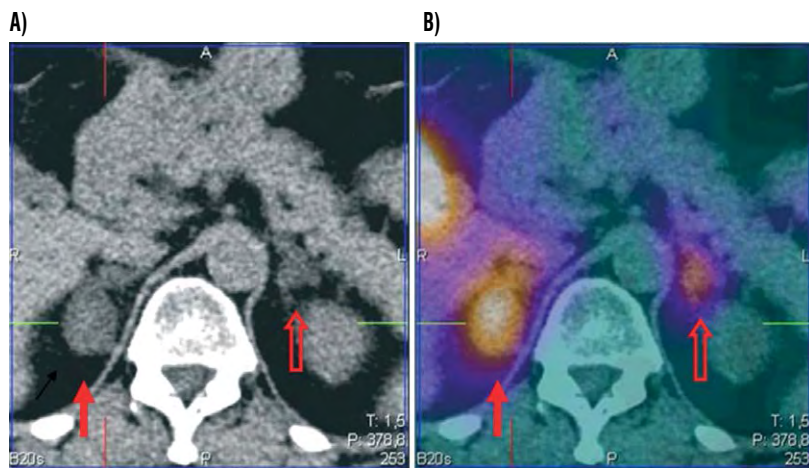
¹³¹I norcholesterol in adenoma (arrow) of adrenal cortex: (A) CT, (B) fusion image (normal adrenal gland: open arrow)
